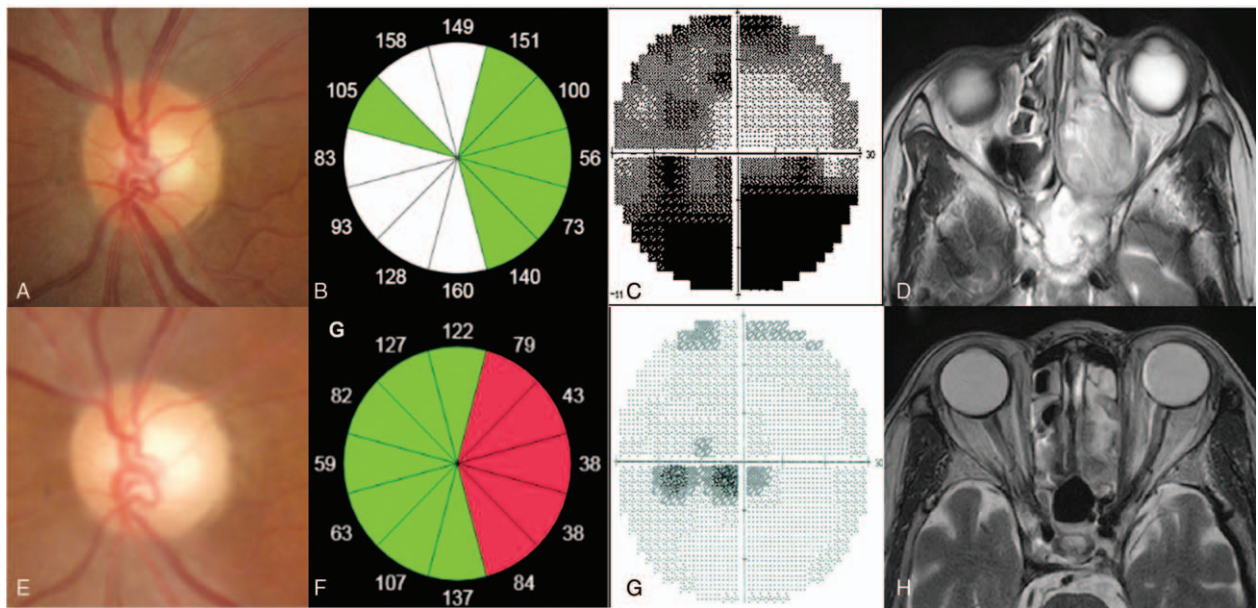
Changes in clinical findings of a patient with Ewing sarcoma involving paranasal sinus. (A–D) Initial examinations. (A) Disc photograph showing normal appearance. (B) Normal peripapillary retinal nerve fiber layer thickness on optical coherence tomography (OCT). (C) Visual field test showing generalized defect sparing center area. (D) Brain magnetic resonance imaging (MRI) (T2-weighted MRI) showing heterogeneously enhancing mass, involving the left ethmoid and sphenoid sinuses, and compressing the optic nerve. (E–H) Two years after completion of all 6 rounds of chemotherapy. (E) Disc photograph showing pale optic disc. Progression of peripapillary RNFL thinning using OCT. (F) Thinned peripapillary retinal nerve fiber layer thickness of temporal area on OCT. (G) Improved visual field showing mild cecentral scotoma. (H) Brain MRI showing near resolution of Ewing sarcoma. Colors (B and F) show percentiles of retinal nerve fiber layer thickness distribution; red 0–1%, yellow 1–5%, green 5–95%, white 95–100%.
